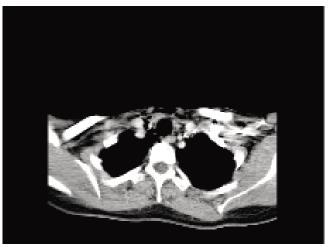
Computed tomography scan with contrast showing subcutaneous emphysema between trachea and oesophagus medially and the carotid sheath laterally.
